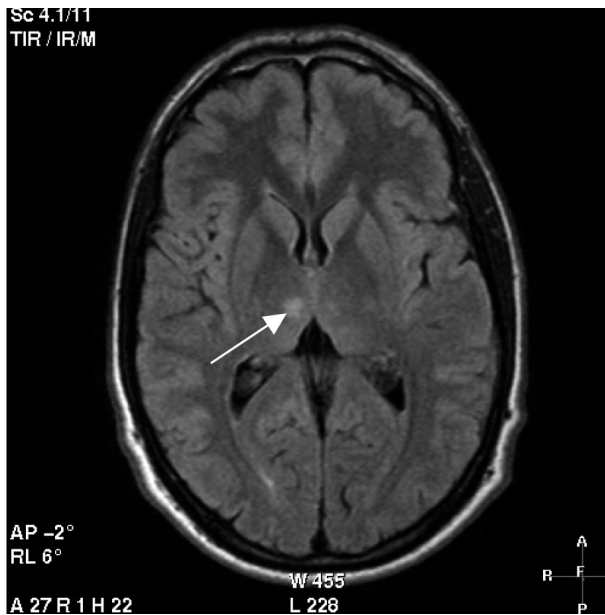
Axial plane magnetic resonance (MR) image obtained with fluid-attenuated inversion recovery sequence, showing signal alteration in the antero-inferior portion of the right thalamus, retrospectively visible in the CT scan. Additional MR images (not shown here) showed the presence of abnormal signals in another zone of the right cerebellar hemisphere. Both lesions suggested ischemic aetiology.
